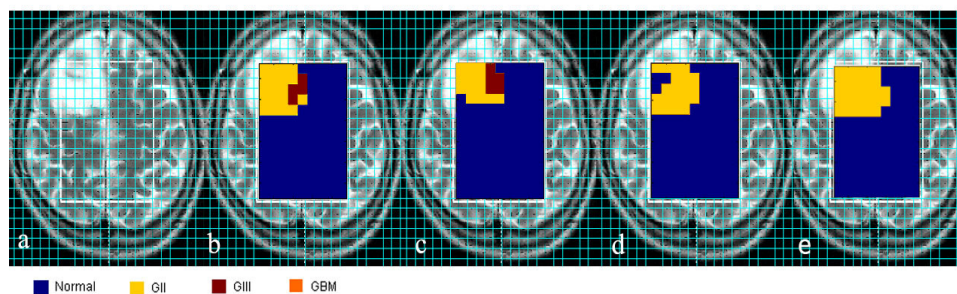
a. T2 MRI image of a brain affected by tumor; nosologic images obtained with CCA for b. all MRSI cases used in building the subspace model, c. only HR-MAS cases are used in building the model, d. all MRSI+HR-MAS cases are used in building the model with data integration approach e. all MRSI and HR-MAS cases are used in building the model with multichannel approach.*
